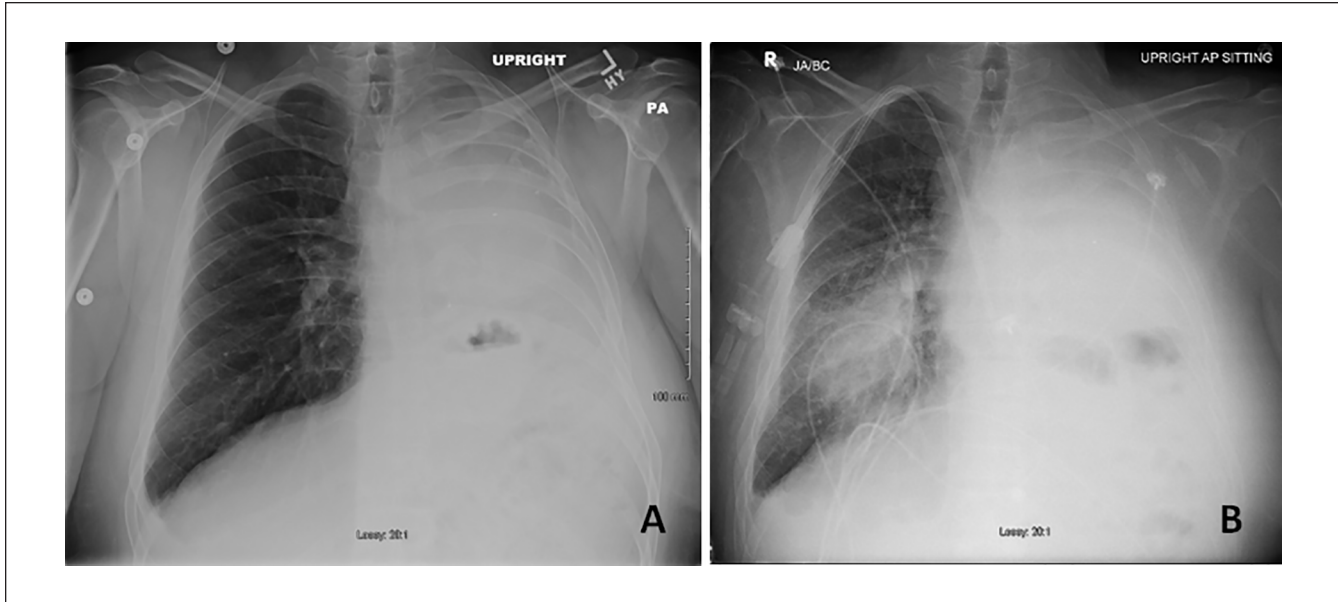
(A) Presenting chest x-ray showing pneumonectomy. (B) Follow-up chest x-ray about 1 year later demonstrating location of severe primary pulmonary coccidioidomycosis for which he tolerated 12 weeks of liposomal amphotericin B.
